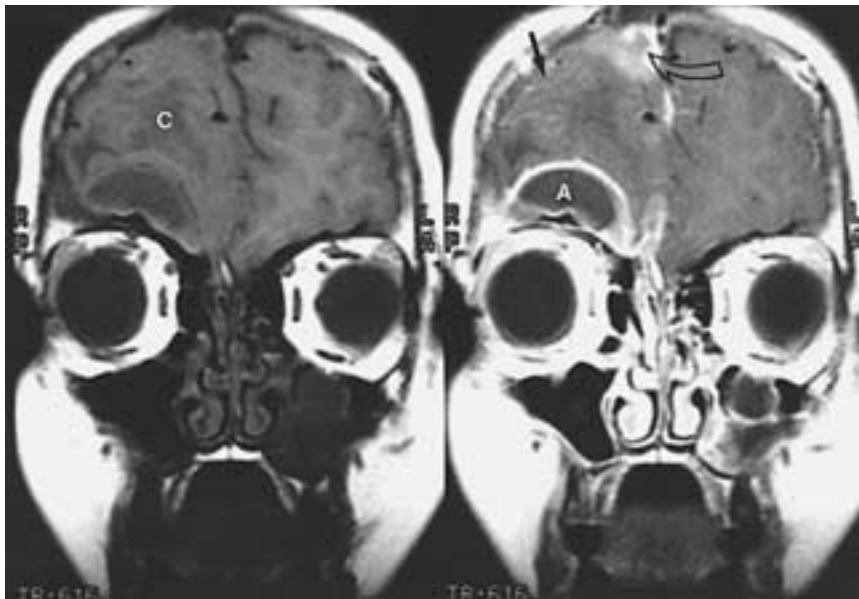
Epidural abscess, cerebritis, and meningitis in a child with acute sinusitis. Pre- and postcontrast-enhanced coronal MR image showing epidural abscess (A), edema adjacent to focal cerebritis (C), and leptomeningeal enhancement (straight arrow) related to meningitis. Note the enhancement of focal cerebritis (curved arrow). (From Eustis HS et al. MR imaging and CT of orbital infections and complications in acute rhinosinusitis. *Radiol Clin North Am* 1998;36:1165–1183.)
